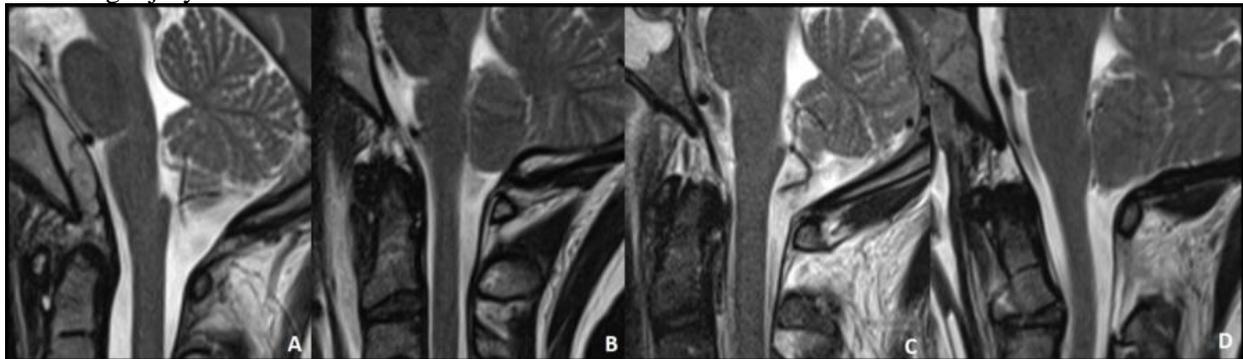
sagittal T2-weighted MRI of pediatric stripped tectorial membrane (type 1 TM injury) with retroclival location and REH
